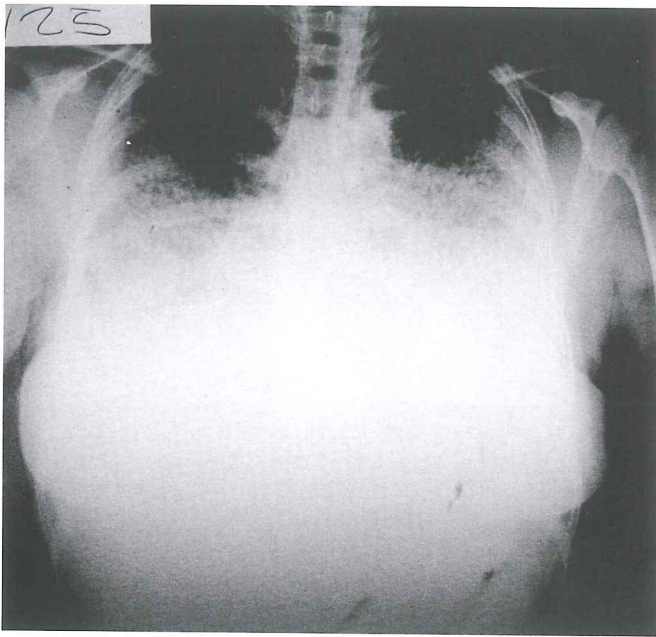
Chest x-ray of index patient's sister
